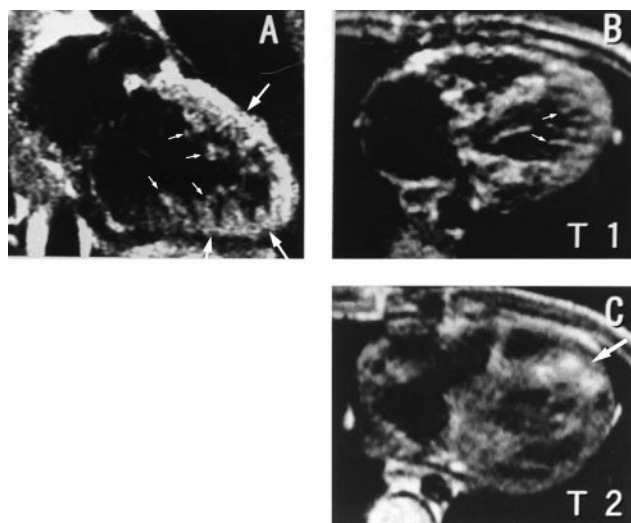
A representative magnetic resonance image (MRI) of a patient with INVM (case 3, Table 1), T1-weighted coronal image (A) and axial image (B) of the left ventricle. An inner zone of noncompacted myocardium (small white arrows) is distinguishable from a thin outer zone (white arrows) of compacted myocardium in the left ventricle. T2-weighted imaging (C) reveals a high-intensity area at the apex (white arrow) consistent with disturbed microcirculation due to fibrosis, thrombus formation, and hypokinesis of this area.
